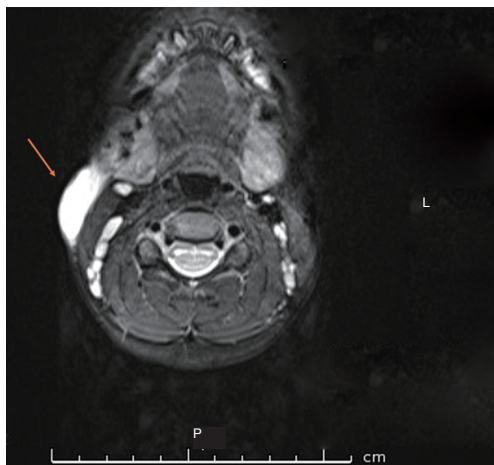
Diagnostic T2 axial MRI image of neck showing a hyperintense signal from the lesion and the superficial fluid collection (arrow). L, left; P, posterior; MRI, magnetic resonance imaging.
